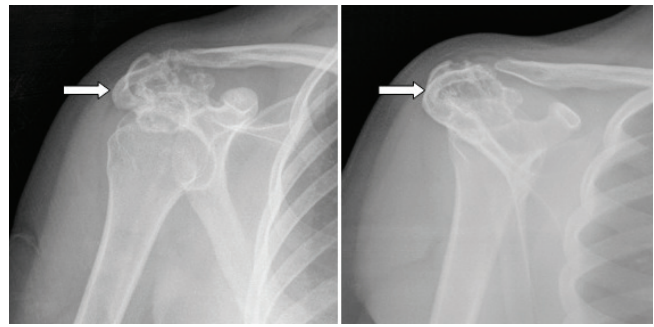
Anterior-posterior radiograph and scapular Y-view of the left shoulder joint demonstrating the osteochondroma protruding into the subacromial space (arrow).
